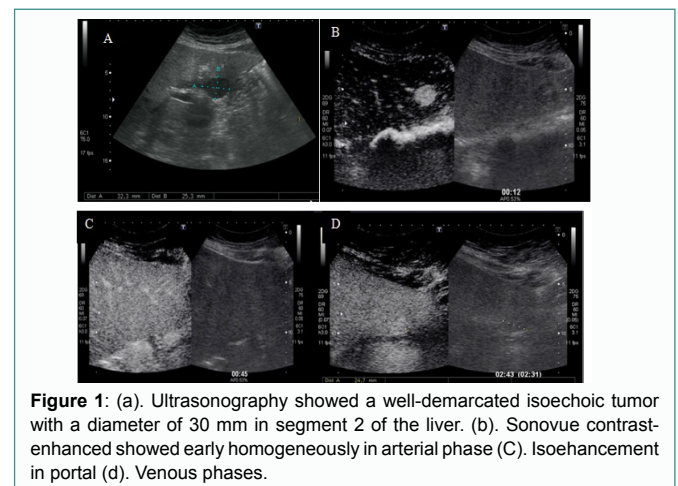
(a). Ultrasonography showed a well-demarcated isoechoic tumor with a diameter of 30 mm in segment 2 of the liver. (b). Sonovue contrast-enhanced showed early homogeneous in arterial phase (c). Isoenhancement in portal (d). Venous phases.
